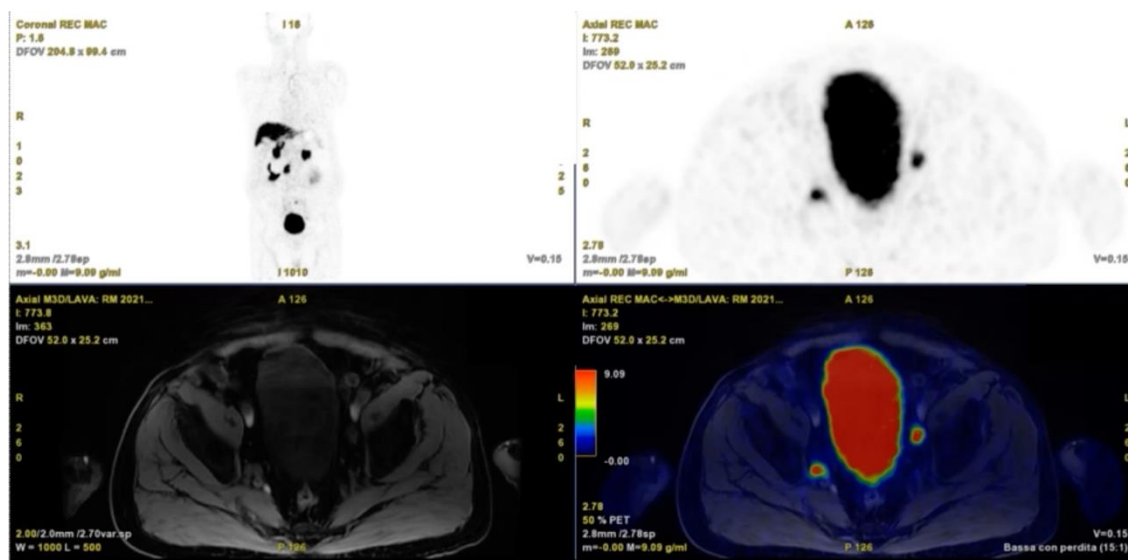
Imaging report of ^{68}Ga -PSMA PET/MRI with evidence of the level of obturator right and internal iliac left nodes.
